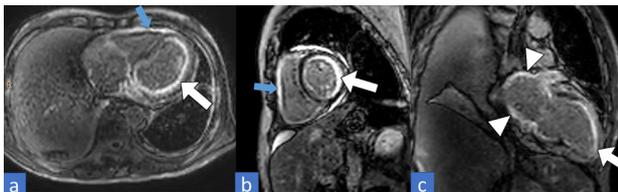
LGE MR images four-chamber view (a), short axis view (b), and vertical long axis two-chamber view showing diffuse subendocardial and transmural myocardial enhancement involving the basal cavity, mid-cavity and apical cavity (white arrow). There was also diffuse enhancement of the right ventricular wall (blue arrows in a and b) and the bilateral atrial wall (arrowheads in c). The contrast enhancement was diffuse and was not pertaining or limited to the vascular territories.
